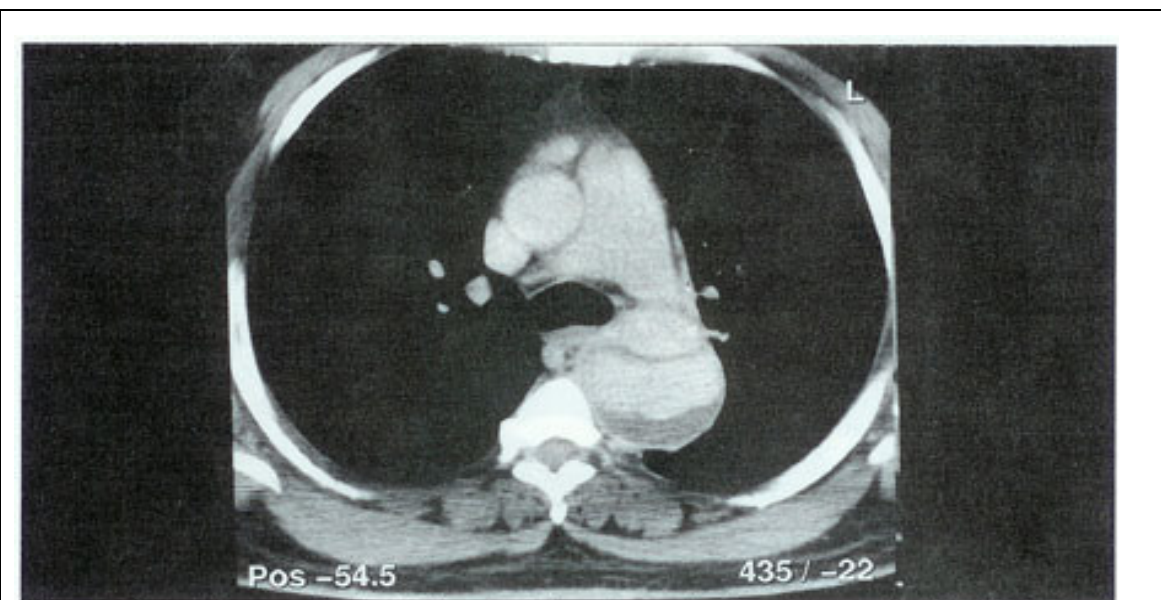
Computed tomography-showing dissection of thoracic aorta. True lumen is antero-laterally while the large false lumen is surrounding the inner 2/3rd residual hematoma also seen posterior to the false lumen.
